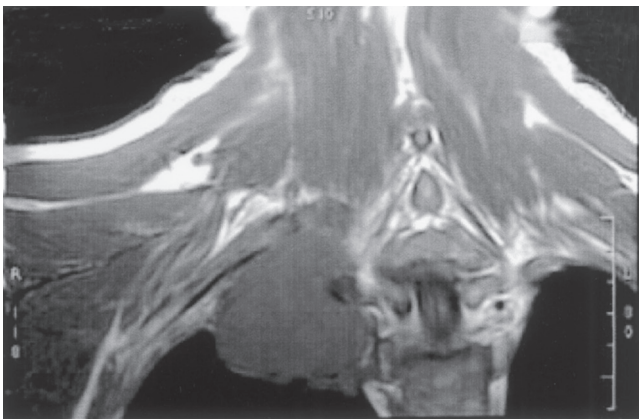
■ Magnetic resonance image showing a left superior sulcus bronchial carcinoma invading the middle thoracic inlet, including the subclavian artery.
